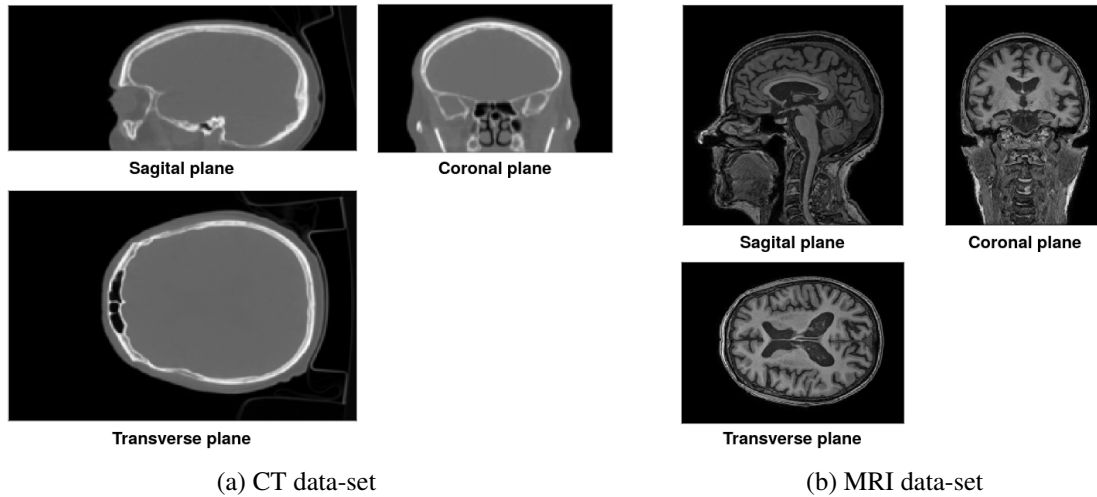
On the left we can see three slices of the CT scan from which we will be trying to segment the cranium, corresponding to the bright white structure. On the right we can find the MRI dataset with many irrelevant tissues for the task at hand that will be removed in the pre-processing phase using the techniques mentioned in the previous chapter.
